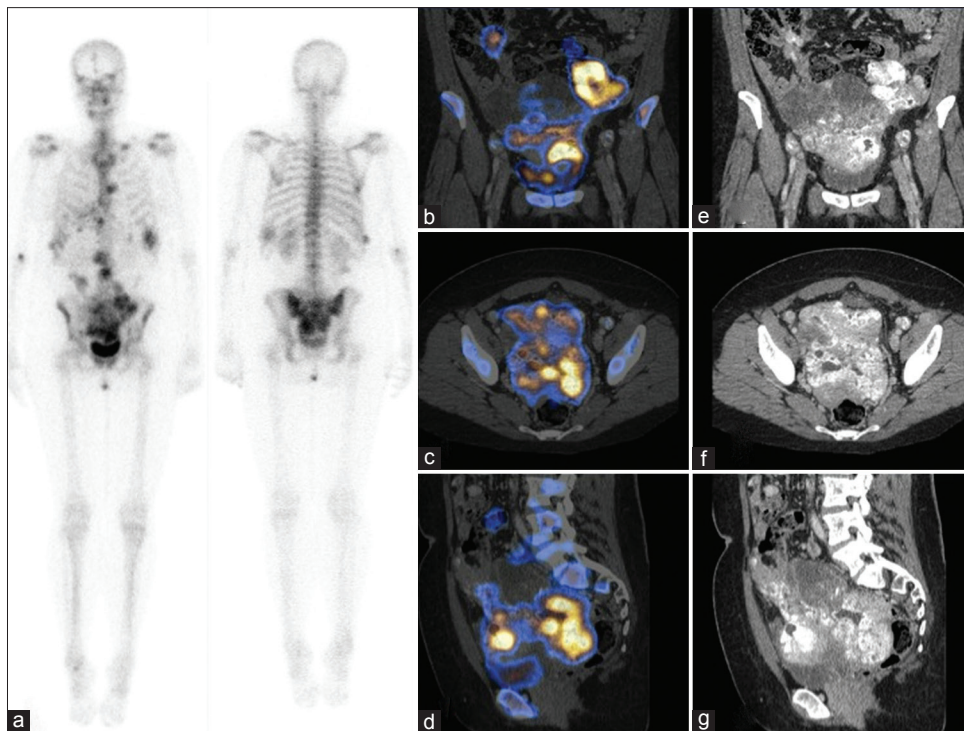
Technetium-99m methylene diphosphonate whole-body bone scintigraphy (a) revealed extensive extraosseous activity throughout the pelvis and abdomen as well as some foci of increased uptake in the thorax. Additional coronal, transverse, and sagittal fused single-photon emission computed tomography-computed tomography images (b-d) precisely visualized radionuclide accumulation in calcified soft tissue masses, without any pathological tracer uptake in the bone. These findings were confirmed by contrast-enhanced computed tomography images (e-g) and consistent with widespread omental and peritoneal calcified tumor implants
